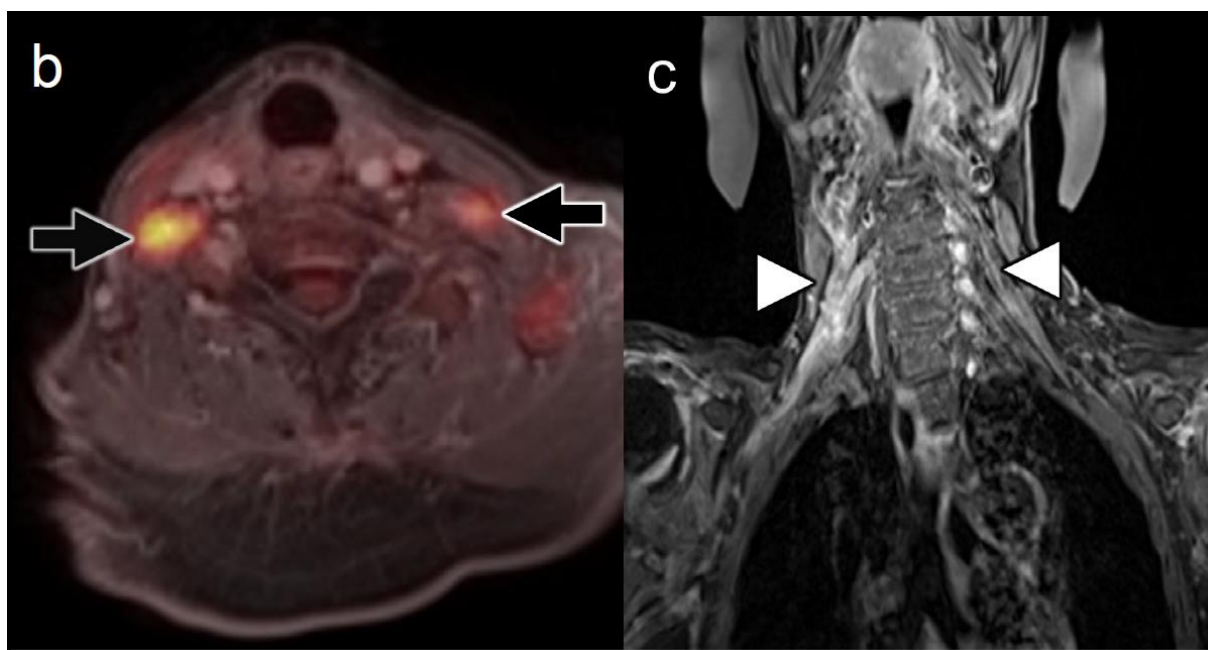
Misleading near-symmetric FDG uptake. Fused coronal FDG-PET/MRI (T1-weighted pre-contrast image) (a) in a patient with biopsy-proven neurolymphomatosis shows bilateral FDG uptake in the brachial plexus (white arrows). Fused axial FDG-PET/MRI (T1-weighted post-contrast fat-saturated image) (b) shows the bilateral FDG uptake within the brachial plexus (black arrows) to be mildly greater on the right. Coronal T1 Dixon post-contrast fast-saturated MRI (c) shows marked enhancement (white arrowheads) of the enlarged (right greater than left) brachial plexus nerve roots. Axial DWI trace (d) shows markedly hyperintense brachial plexus (black arrowheads) bilaterally due to a combination of high cellularity lymphomatous infiltrate and intrinsic fractional anisotropy of the brachial plexus resulting in reduced diffusivity. This case shows the risk in assuming that “symmetry is your friend”; rather, symmetry may be your “frenemy”!
